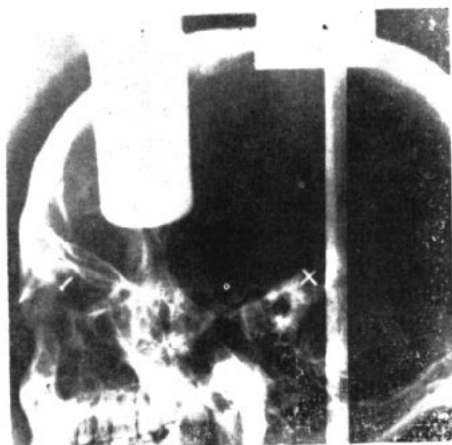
Region of condyle and fossa and its appearance in shadow outline on temporomandibular joint roentgenogram.
